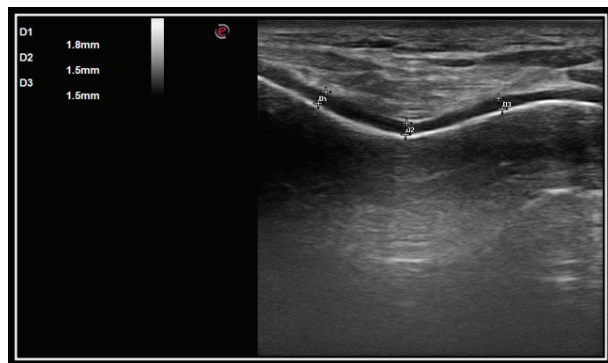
Ultrasongraphic image (suprapatellar axial view) showing right femoral distal cartilage measurements (D1 right lateral condyle, D2 right intercondylar area, D3 right medial condyle).
